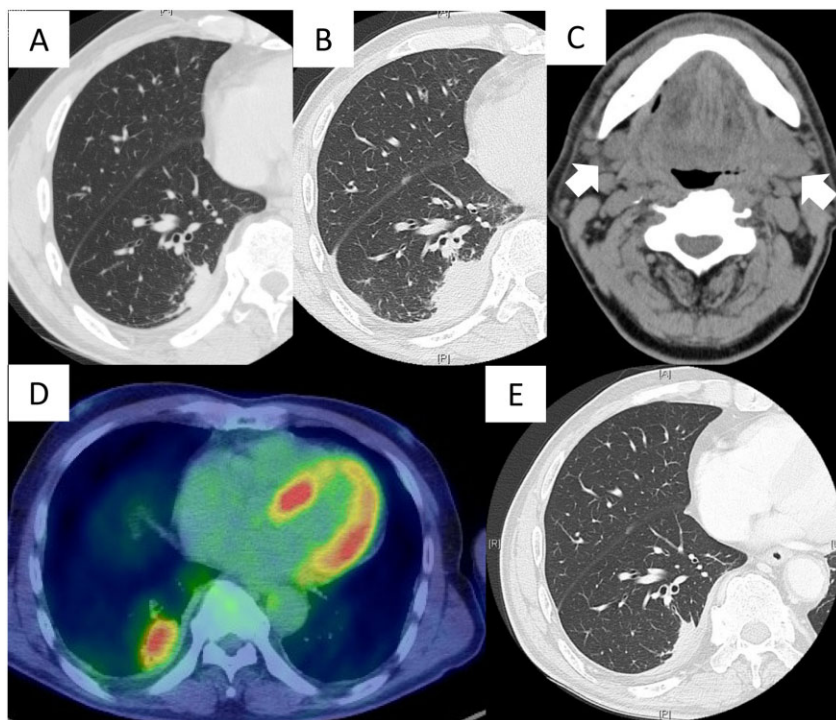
(A) Chest computed tomography (CT) at first visit in 2006 showed a consolidation and pleural thickening in the right lower lobe, which was diagnosed as asbestos-related rounded atelectasis. (B) After 8 years, enlargement of the consolidation was observed. (C) Swelling of submandibular glands was seen on CT (arrows). (D) Positron emission tomography/CT showed increased uptake of 18-fluorodeoxyglucose in the consolidation. (E) Two months after the administration of PSL, the consolidation improved, whereas the rounded atelectasis persisted.
